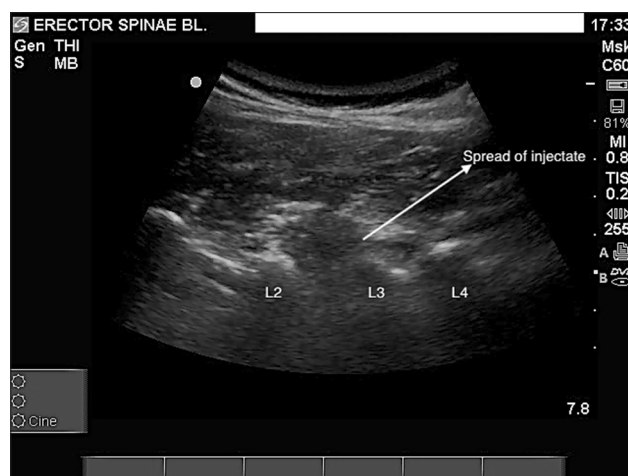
Ultrasound-guided lumbar erector spinae plane block
